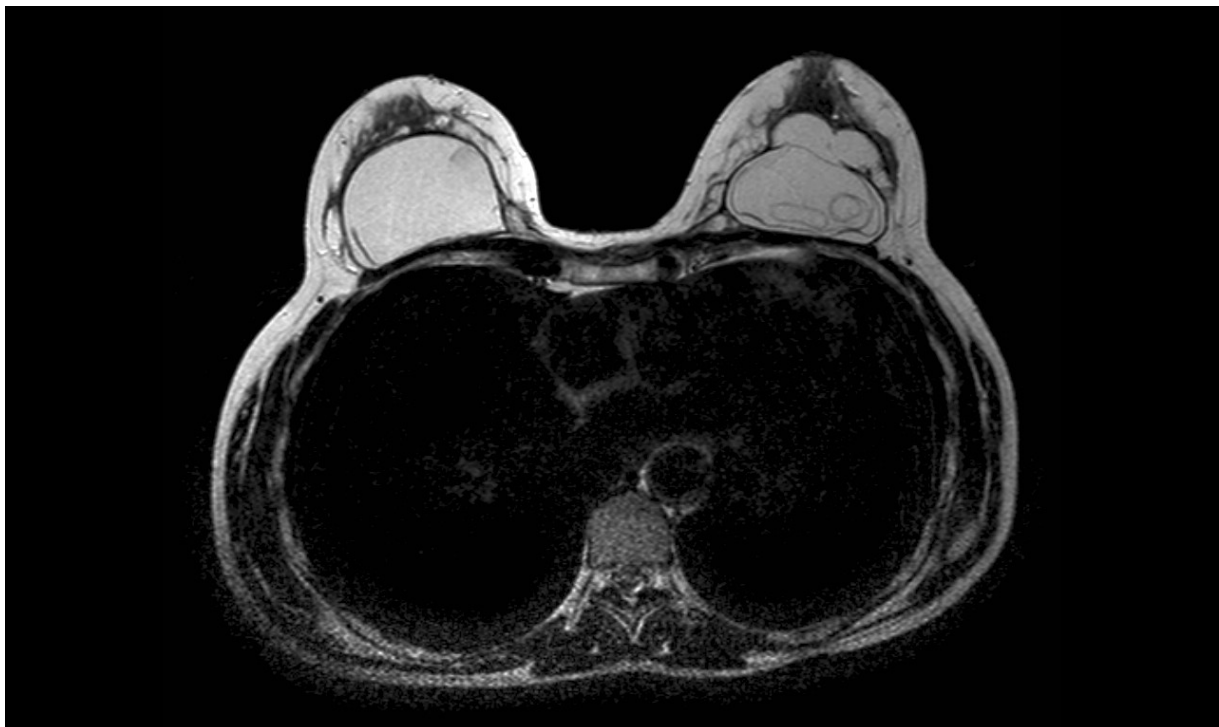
MRI showing intra- and extracapsular rupture of traditional round soft silicone gel-filled breast implants.
